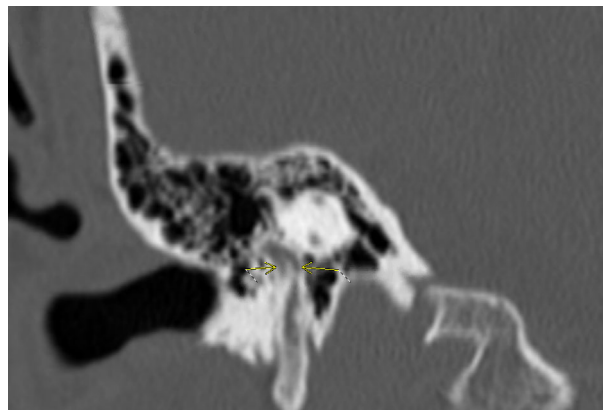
Coronal computed tomography temporal bones showing bifurcation of vertical segment of the right facial nerve through two separate bony canals.
